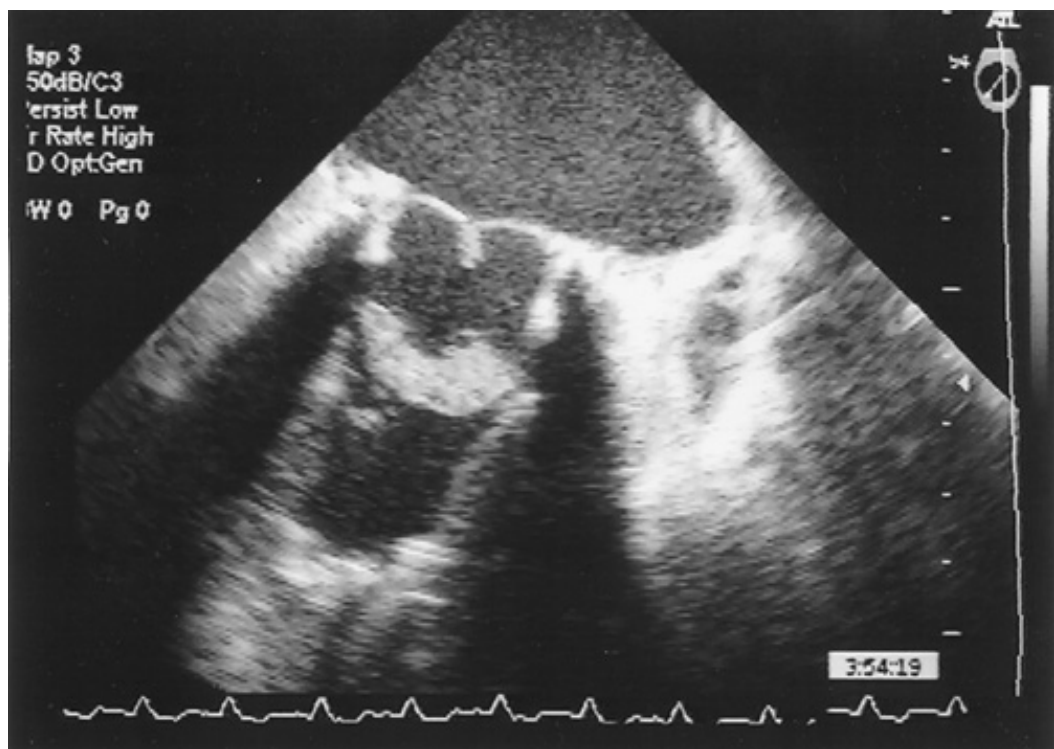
Transesophageal echocardiogram from a patient with eosinophilic endocarditis and prosthetic mitral valve replacement. Thrombus is noted below the valve struts, which at the time of surgery was found to be adherent to the posterior LV wall. Note the apical obliteration and the apical endocardial thickening and calcification.
